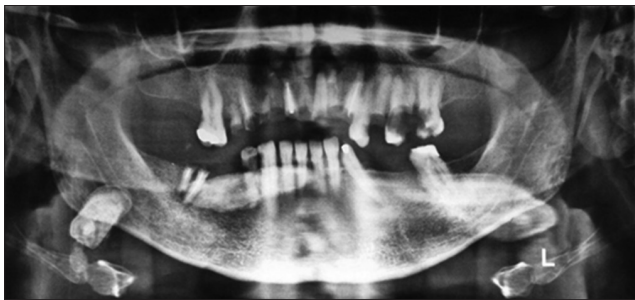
Orthopantomograph images revealed multiple unilateral salivary stones in the submandibular glands
